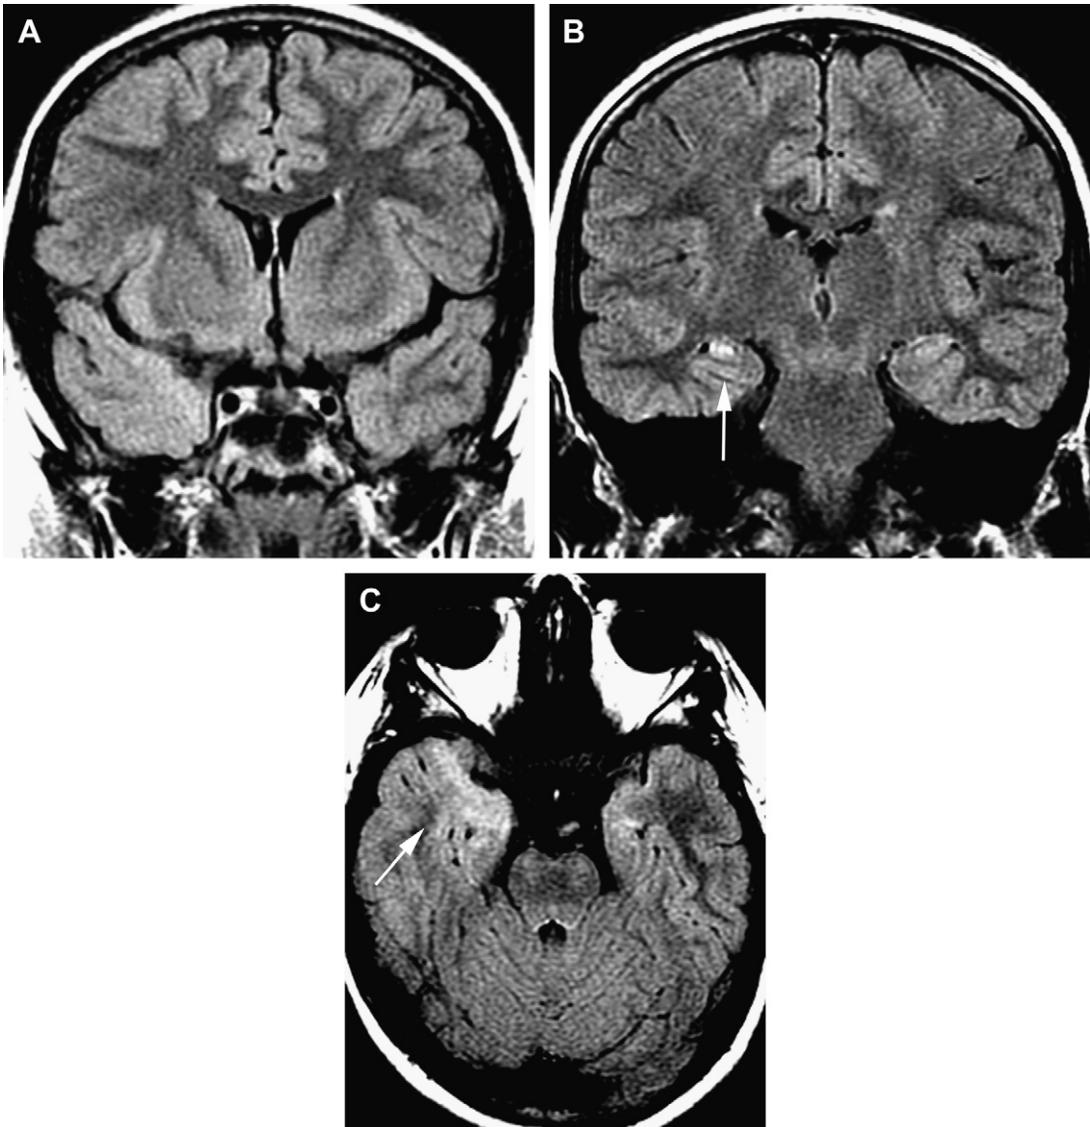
FCD IIIA. (A) Coronal FLAIR. The normal low signal of the anterior temporal white matter is lost on the right side. (B) Coronal FLAIR. This posterior coronal image demonstrates a bright signal and atrophy of the right hippocampus (*arrow*). This association of hippocampal sclerosis and adjacent likely FCD of the temporal lobe characterizes FCD IIIA. (C) Axial FLAIR. Ill-demarcated bright signal of the anteromedial temporal pole (*arrow*).
